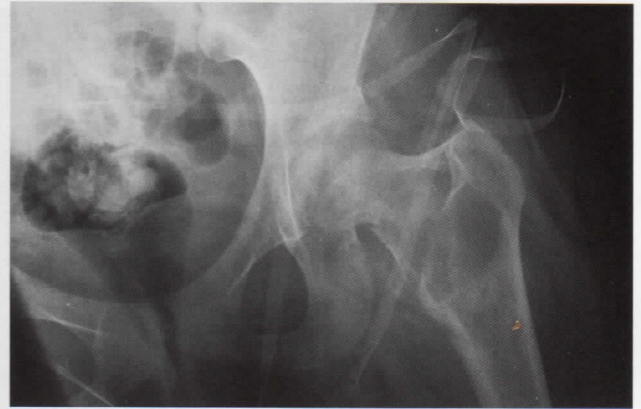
Anteroposterior radiograph of the affected hip showing the pathologic fracture at the femoral neck.
